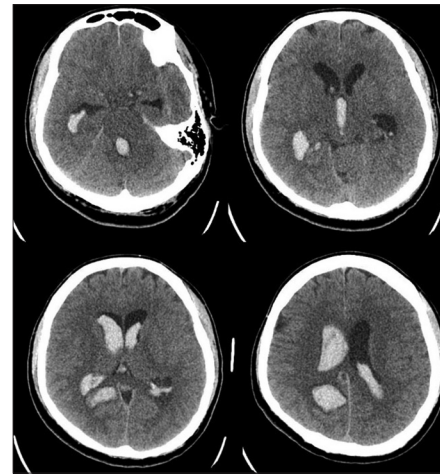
Case #1 Presenting axial non-contrast CT scan showing large amount of IVH
